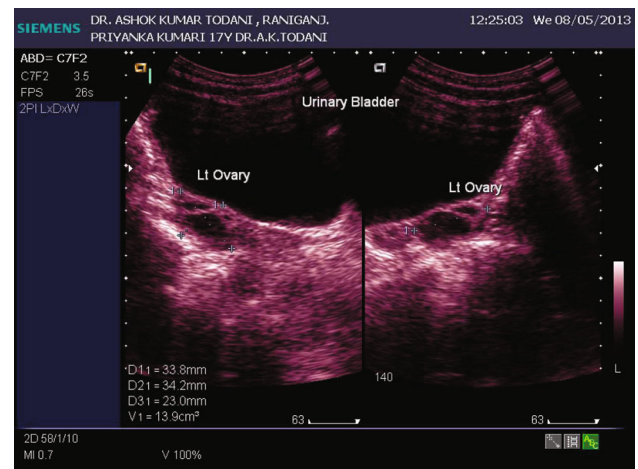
Transabdominal pelvic ultrasound (left ovary)
